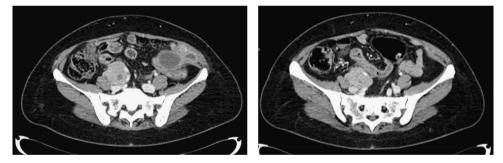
Baseline and 3 months CT scan in hENT1 overexpressing leiomyosarcoma patient treated with gemcitabine. This patient was diagnosed with a retroperitoneal leiomyosarcoma with multiple peritoneal nodules and lung metastasis since the first diagnosis. The patient progressed after first line anticancer therapy with adriamycin and trabectedin as second line. With gemcitabine monotherapy the patient achieved a RECIST partial response.
